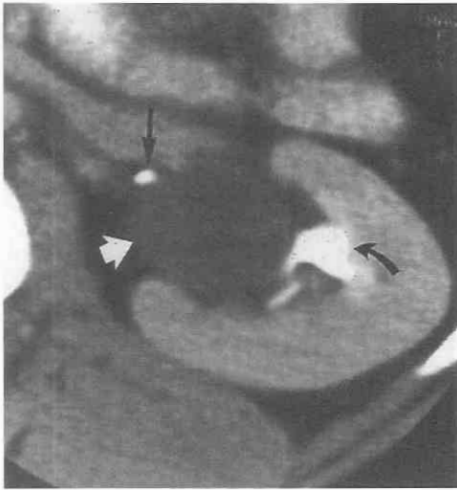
Renal sinus (parapelvic) cyst. A contrast-enhanced CT scan reveals that the cyst (*white arrow*) is surrounded by a halo of renal sinus fat, indicating its extrarenal origin. The nondilated collecting system (*curved arrow*) and ureter (*long arrow*) are displaced by the cyst.
